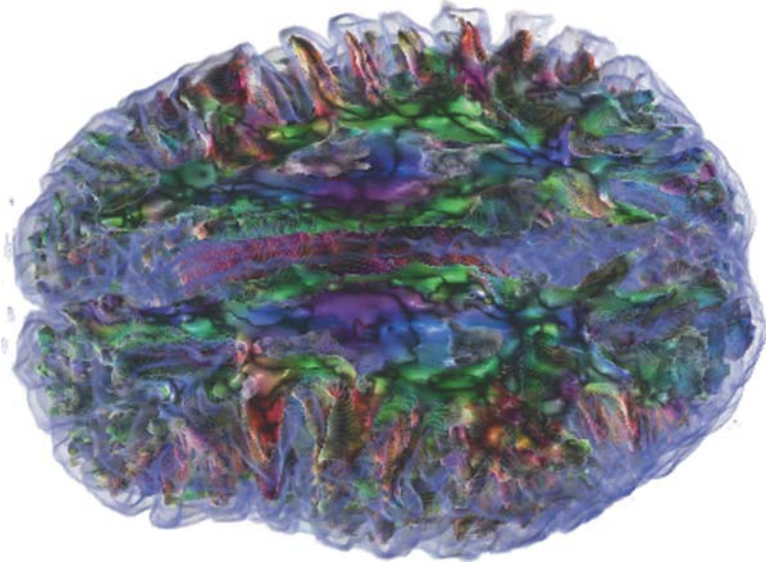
Overview of gyri clipped by an almost axial clipping plane. (RGB color coding of DTI and clipping of DTI data based on FA value of 0.3 as used in many fiber-tracking algorithms.) A semi-transparent surface was extracted from the original MRI data set visualizing the boundary of the brain
